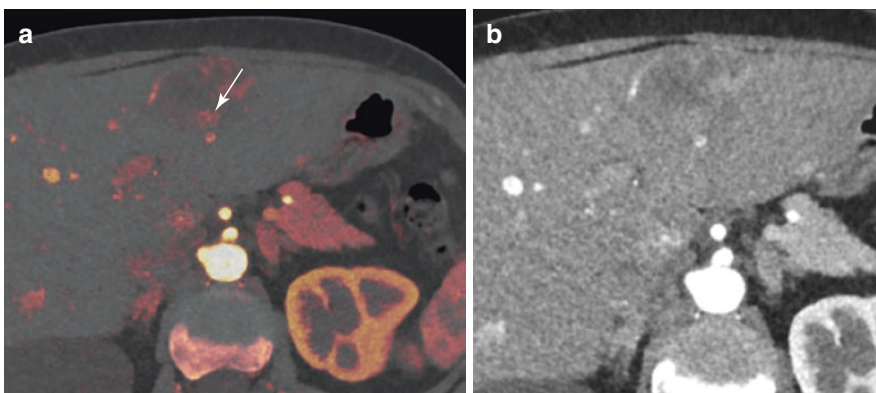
Post-processed contrast map (a) shows peripheral viable tissue (arrow) in a hypodense lesion in the left liver lobe, improving the detection of the peripheral enhancement compared to contrast-enhanced CT in the arterial phase (b)
